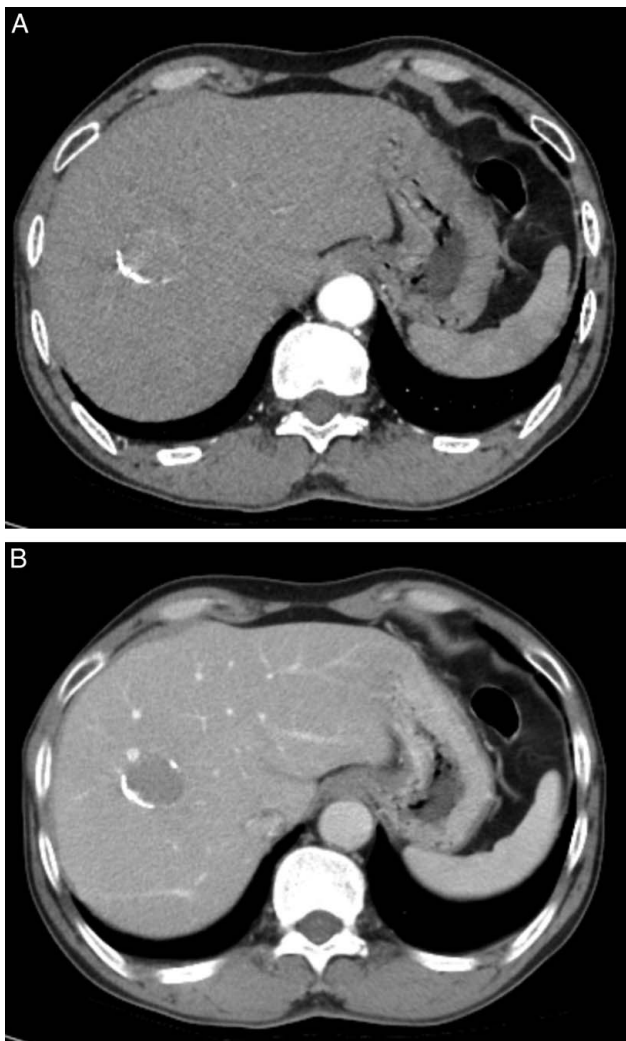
Computed tomography scan revealed a 26 × 29 mm mass in subsegment VIII, exhibiting enhancement during arterial phase imaging with peripheral calcification (similar to liver parenchyma) (A), and subsequent drug withdrawal during venous phase imaging (B).
